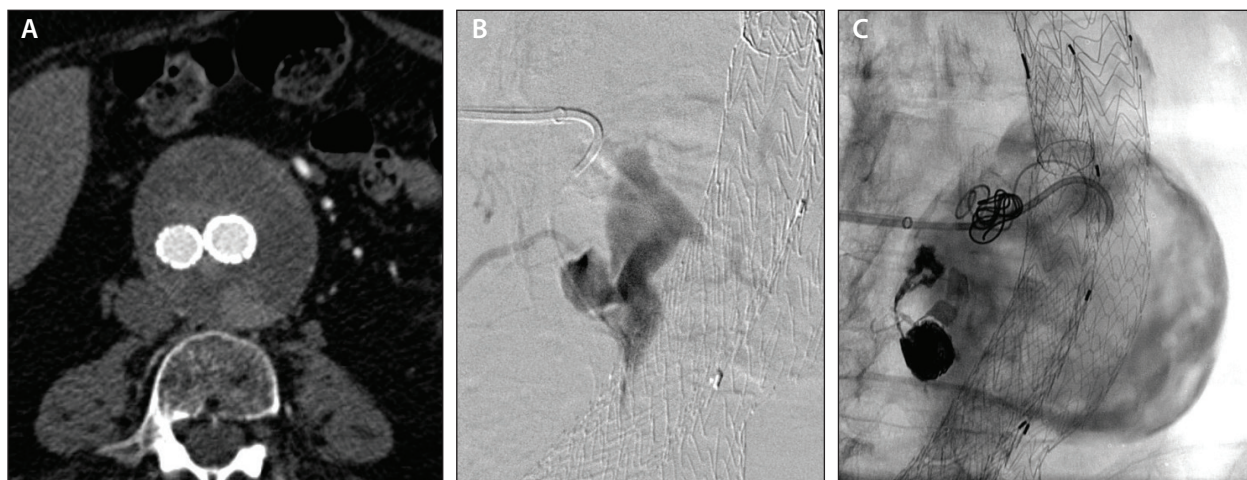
A male patient in his late 80s with type II endoleak on CTA via the L3 lumbar arteries (A). A transarterial approach was not amenable due to prior IIA aneurysm embolization and stent graft extension (A). Translumbar access was obtained with a 21-gauge Chiba needle and 0.018-inch microwire. This was then exchanged for a short sheath, RIM catheter, and Glidewire (Terumo Interventional Systems). DSA demonstrated nidus filling with contrast extending into the paired L3 lumbar arteries (B). A combination of pushable coils and 4:1 NCBA glue administration were used to embolize the nidus. The glue flowed into the proximal branch vessels of the lumbar arteries, providing appropriate embolization (C).
